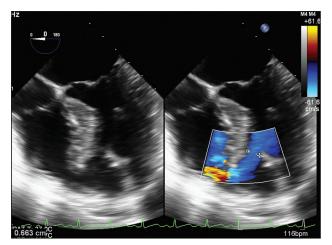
The 7 mm ventricular septal defect (post-myocardial infarction) in mid-esophageal four chamber view with color flow Doppler for comparison
